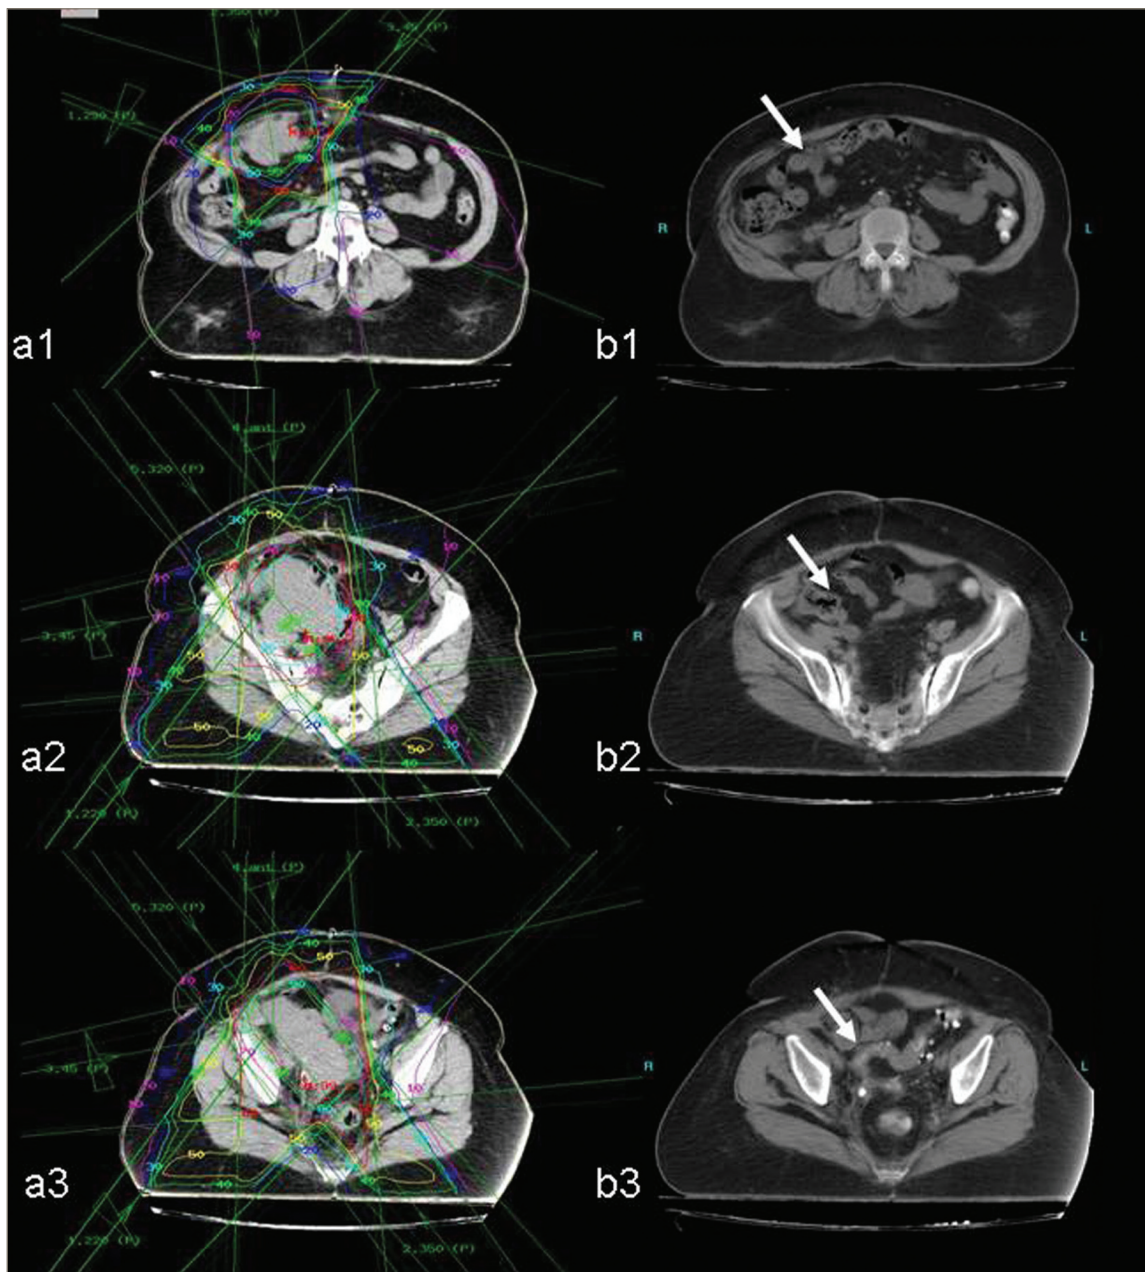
CT-images of abdominal (a1) and pelvic (a2, a3) tumoral masses from recurrent endometrial carcinoma showing the fields and isodose curves of the radiotherapy performed . Complete response of the tumor masses is evident (arrows) at CT-scan performed 4-years after therapy (b1, b2, b3).
